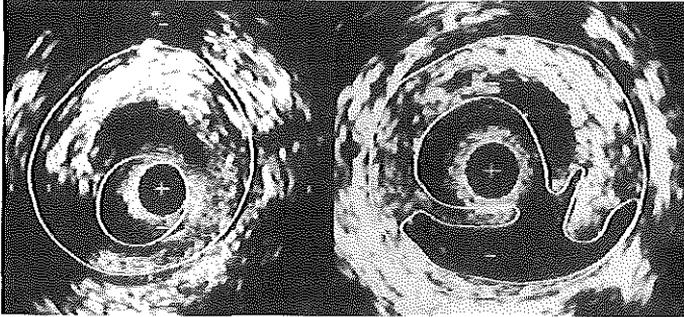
Intravascular ultrasound cross-sections obtained before and after balloon angioplasty in vivo. According to the definition the plaque was defined eccentric. + = catheter; calibration = 1 mm.
